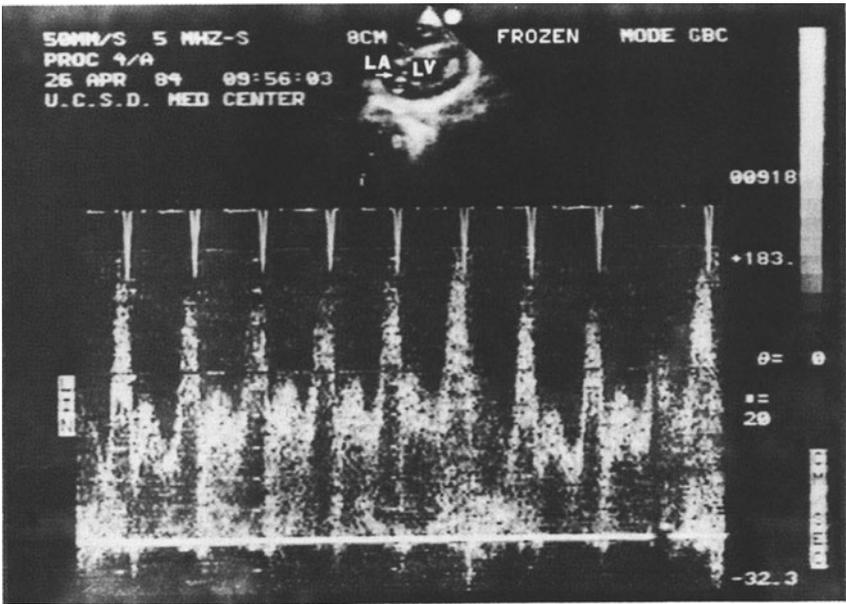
Intraoperative echocardiography study shows a combination of imaging and Doppler in evaluating a patient with obstruction of the anastomosis of a common pulmonary vein to the left atrium 1 year after a primary repair for TAPVD. In the intraoperative study performed before the revision of the anastomosis, the connection of the common pulmonary vein (CPV) to the left atrium appears narrowed. The
